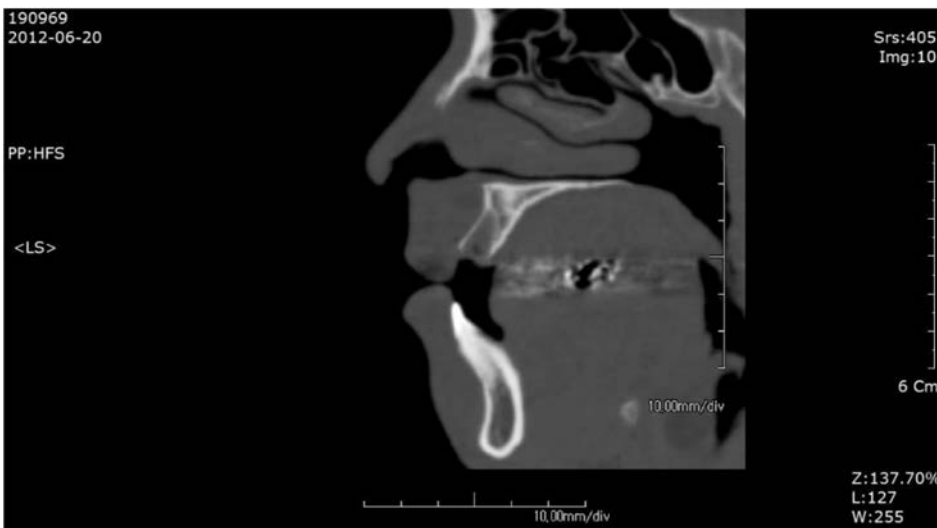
CT view of initial examination.
